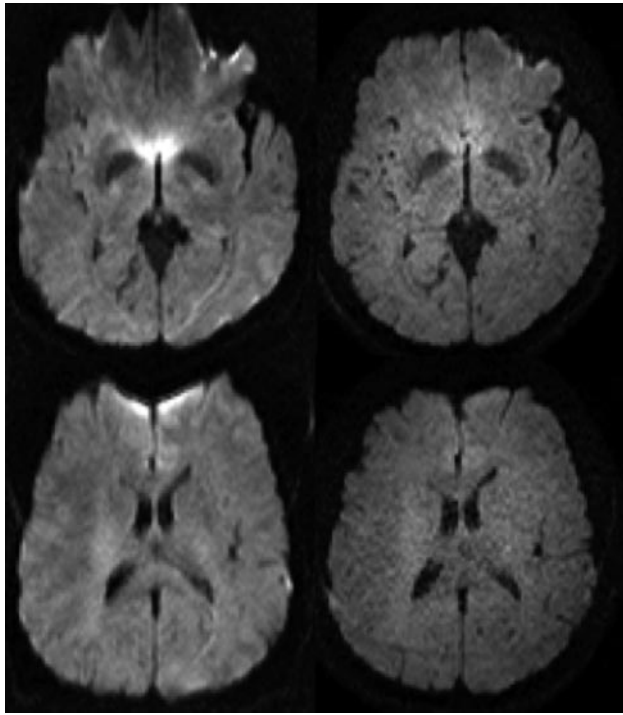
Diffusion-weighted MR imaging at 3T: the left column shows 2 transverse sections acquired without sensitivity encoding (SENSE), whereas the right column shows the same sections acquired with a SENSE factor $R = 3$. Note the much smaller geometric distortion in the SENSE images because of the shorter acquisition time.
